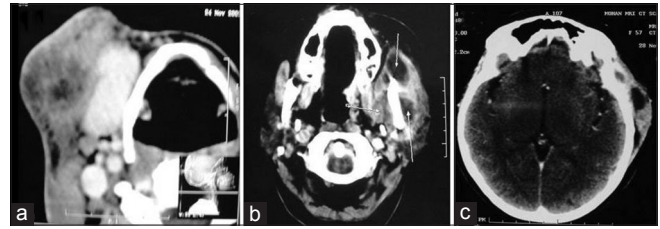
(a) Axial computed tomography (CT) scan shows massive swelling of the masseter muscle and the parotid gland associated with a region of slightly lower attenuation in the muscle. (b) Axial CT scan shows areas of lower attenuation within the region of parotid gland highly suggestive of abscess. (c) Axial CT scan shows a low attenuation area beneath the body of mandible in submandibular region
